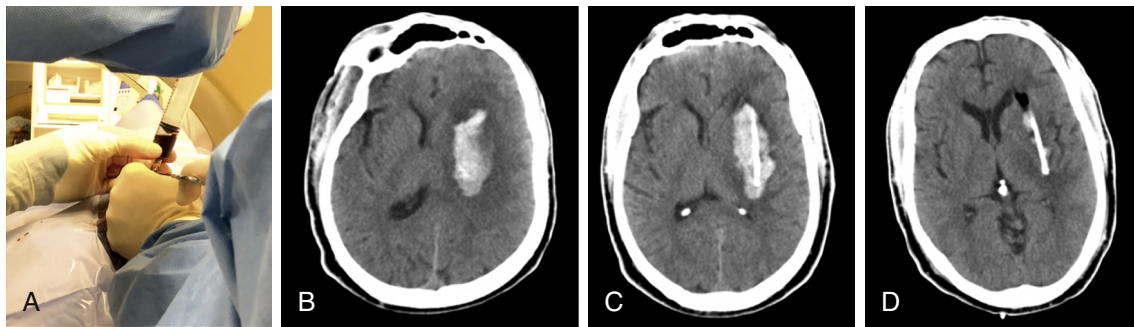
MISTIE catheter placement. (A) Hematoma aspiration during the MISTIE procedure with a Dandy needle under real-time imaging in CT procedure room, incrementally confirming placement and hematoma. (B) Axial CT scan showing a 37-mL intracerebral hemorrhage. (C) After aspiration and subsequent placement of the MISTIE catheter (good placement with all catheter perforations engaged within the clot). (D) Hematoma evacuation to final volume of 1 mL after three doses of recombinant tissue plasminogen activator. (Reproduced with permission from Awad IA, Polster SP, Carrion-Penagos J, et al. Surgical performance determines functional outcome benefit in the Minimally Invasive Surgery Plus Recombinant Tissue Plasminogen Activator for Intracerebral Hemorrhage Evacuation (MISTIE) procedure. *Neurosurgery*. 2019;84(6):1157–1168.)
